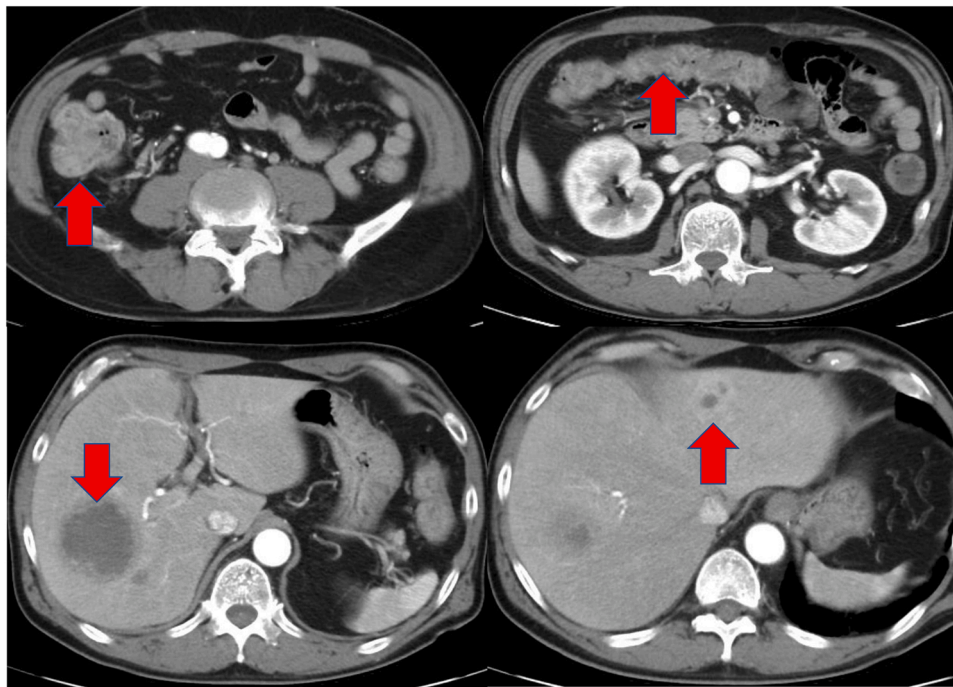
Computed tomography scan of the patient's abdomen on day 14. The scan reveals severe intestinal edema from the ascending colon to the transverse colon of the large intestine as well as many contrast-enhanced low-density area on the liver.
